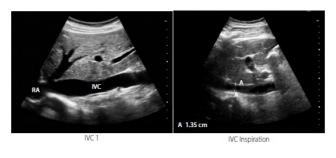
US image of IVC at R atrium (IVC1); IVC inspiration; IVC expiration Source: Used with permission from Partners in Health Manual of Ultrasound for Resource Limited Settings
